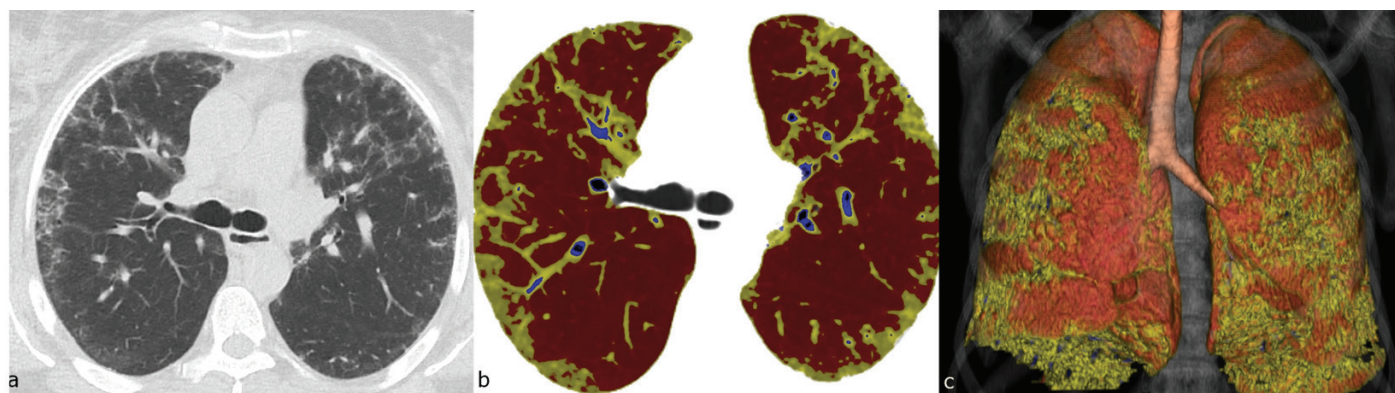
Involvement with peripherally located patchy fine reticulations is seen after treatment on axial HRCT section from carina level (Case 3) (a). In the quantitative analysis of the same section, threshold values corresponding to -200 to -700 HU are represented in yellow (b). Three-dimensional and color quantitative analysis of the same patient (c)
